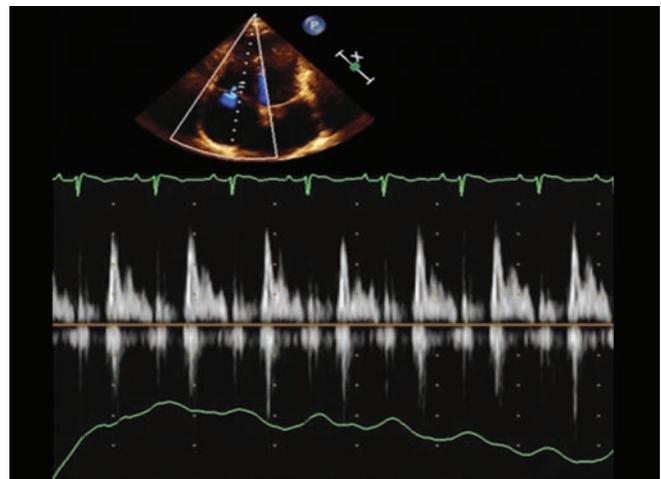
Tricuspid flow Doppler.
